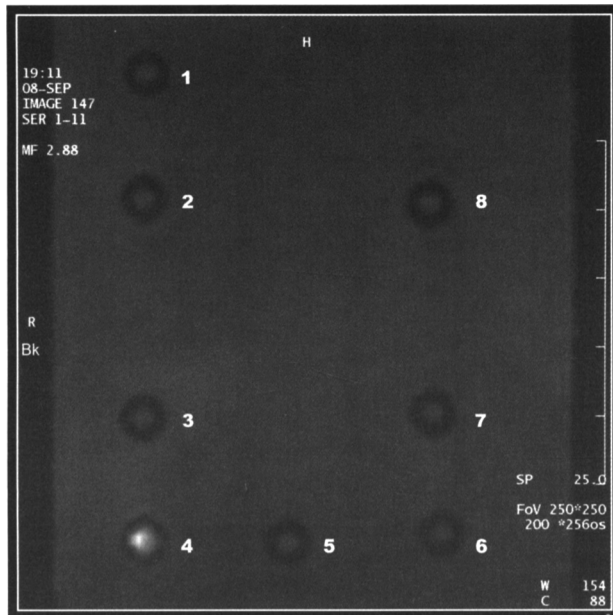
Magnetic resonance imaging analysis performed on HSV infected or uninfected Vero cells, embedded in agarose slice. Wells 1-3: agarose slice controls (1, PBS; 2, H_2O ; 3, 0.9% NaCl); 4, HSV-infected Vero cells incubated with Fab-HSV45/ $Gd^{3+}Cl_6$ antibody; 5: Uninfected Vero cells; 6: Uninfected Vero cells incubated with Gd-DTPA; 7: Infected Vero cells incubated with Gd-DTPA; 8: Uninfected Vero cells incubated with Fab-HSV45/ $Gd^{3+}Cl_6$ antibody.
